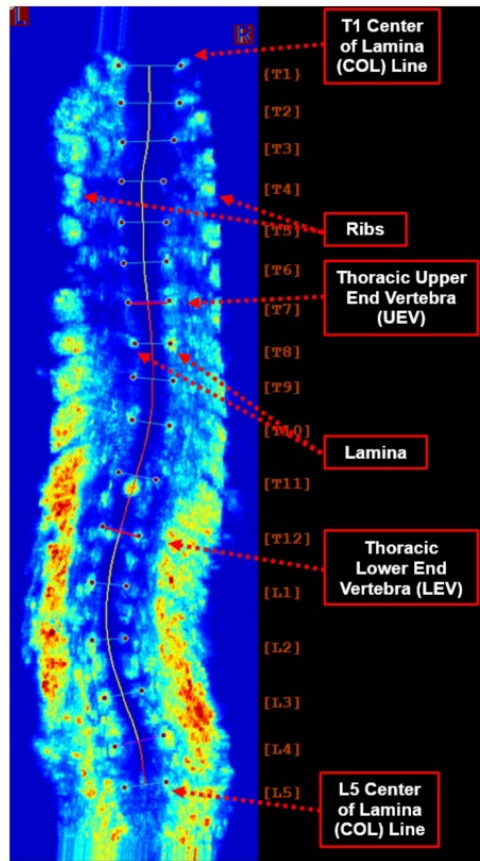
Frontal view of an ultrasound image in standing containing the hyperechoic regions corresponding to the ribs and lamina.
